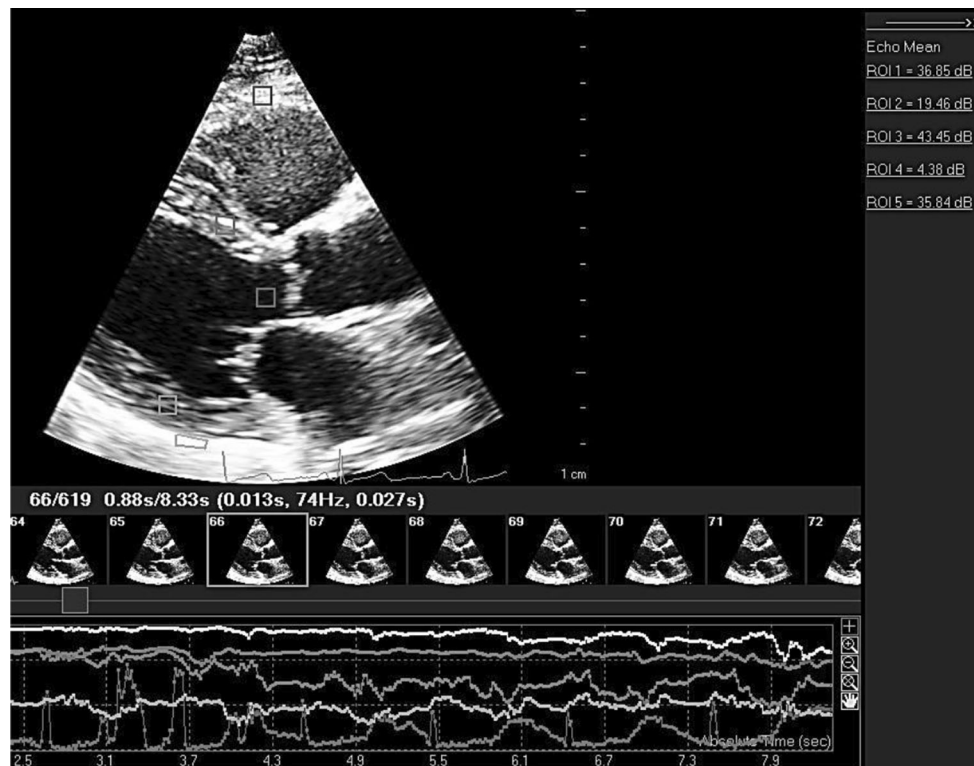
The parasternal long axis clip is frozen at the end of diastole and scrolled to the frame where mitral valve closes. Region of interests (ROI) are set in septum, posterior wall, pericardium, left
